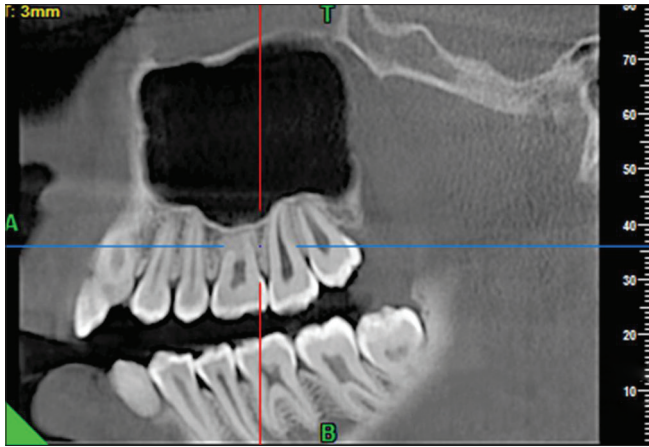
A multiplanar reformatted sagittal cone beam computed tomography image of healthy maxillary sinus with its complement of teeth
